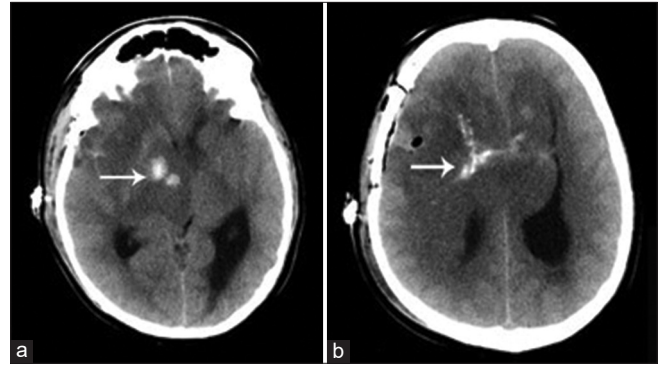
Plain computed tomography axial images (a and b) showing coarse calcifications within parts of the lesion (white arrows). Postcraniotomy and biopsy changes are also visible on the right side.
